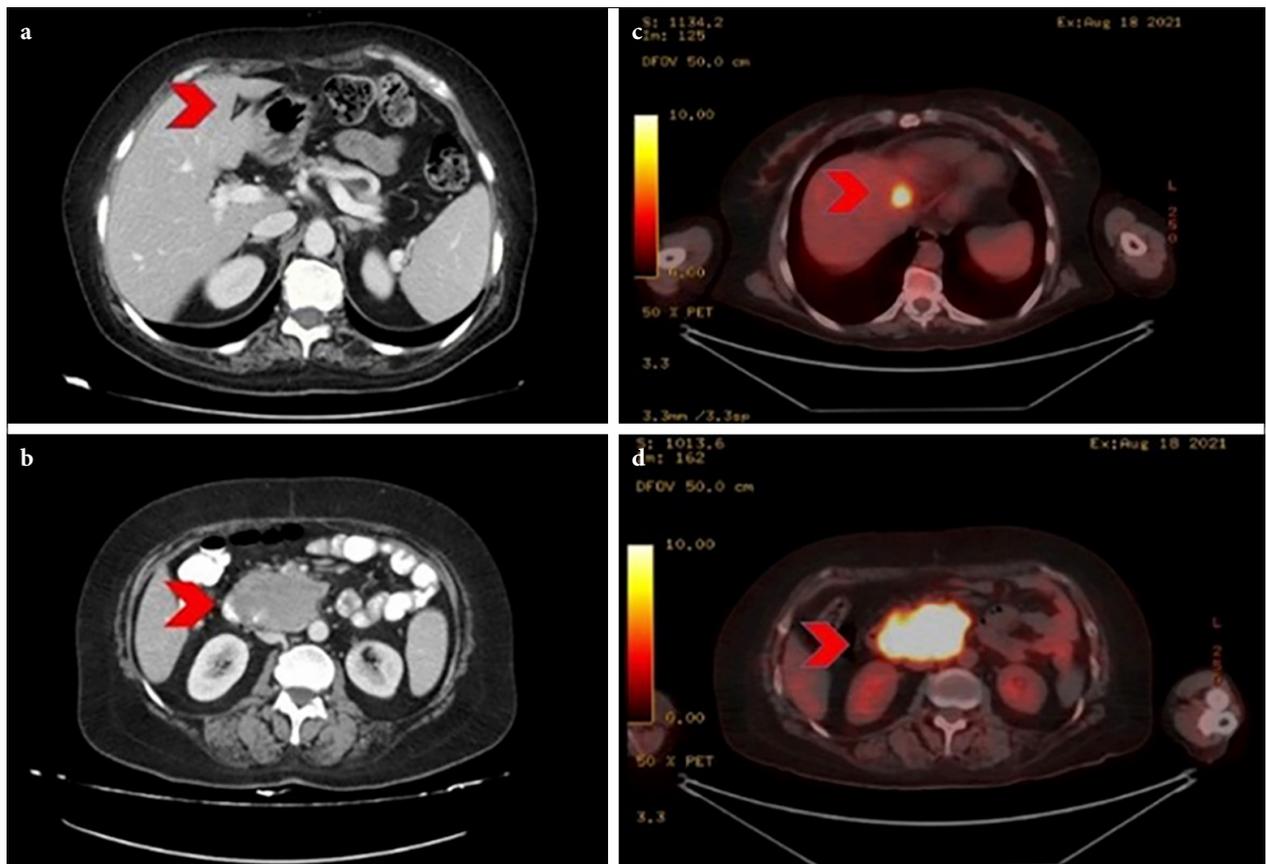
(a) Abdominal CT imaging showing a metastatic nodule in the liver and (b) a large solid mass arising from the duodenum in the right upper quadrant, (c) pre-chemotherapy 18-FDGPET/CT showing liver metastasis and (d) intraabdominal infiltration.
